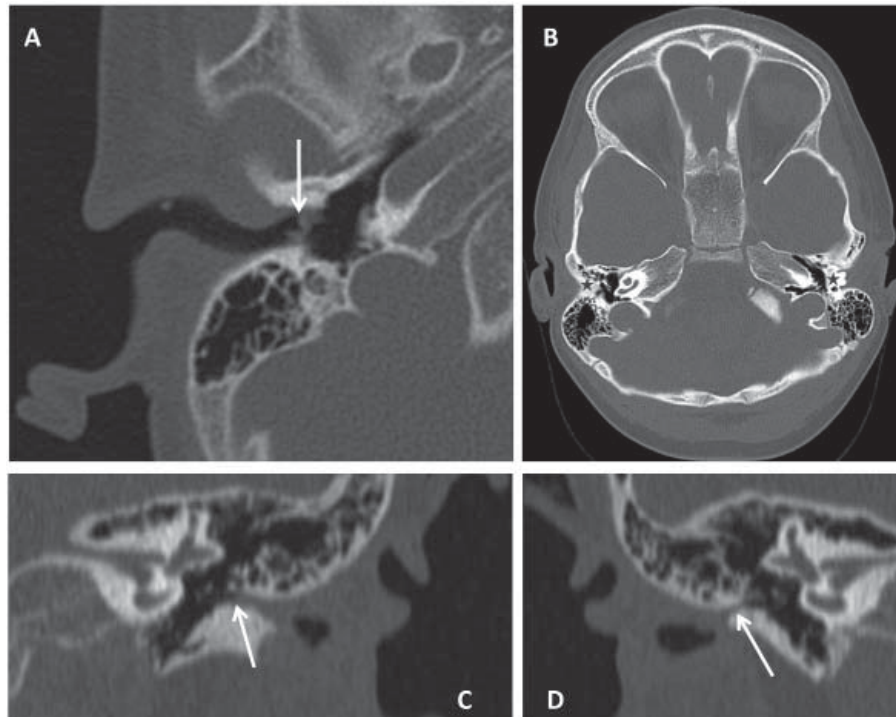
CT scan images of individuals with an 18q deletion or *TSHZ1* mutation. An axial CT scan of individual 1 (A) shows a narrow external auditory canal with a normal tympanic membrane and a grommet (white arrow) in place of the right ear. (B) shows an axial-plane bilateral CT scan of individual 5 with bilateral CAA type IIA (stars). (C) shows a coronal CT reconstruction of individual 7, demonstrating a CAA type IIA (arrow) and (D) shows a coronal CT reconstruction of individual 8, demonstrating a CAA type IIA (arrow).
